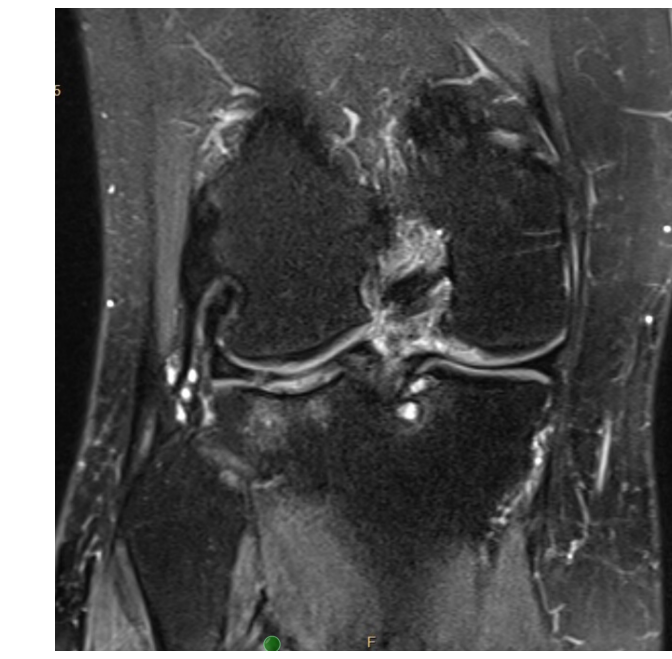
MRI Image of BME- Case 3
